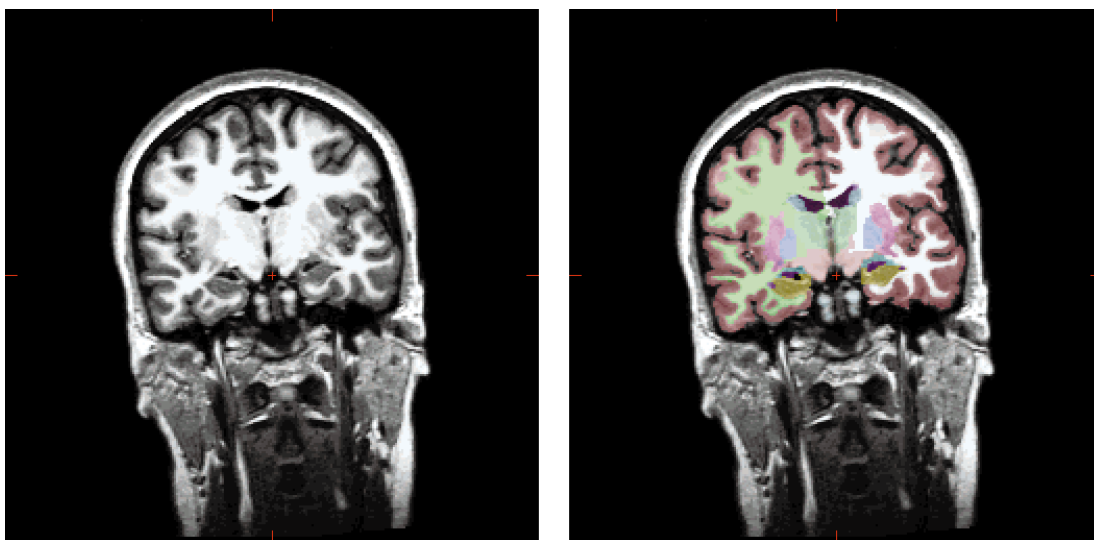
Sample of automated labelling (right picture) of a skull-stripped T1 weighted MRI picture (left picture). Hippocampus (yellow areas), cerebral cortex (violet areas), and white matter (white/light green areas) are shown in one slice in the coronal view of the brain of a young female participant.
